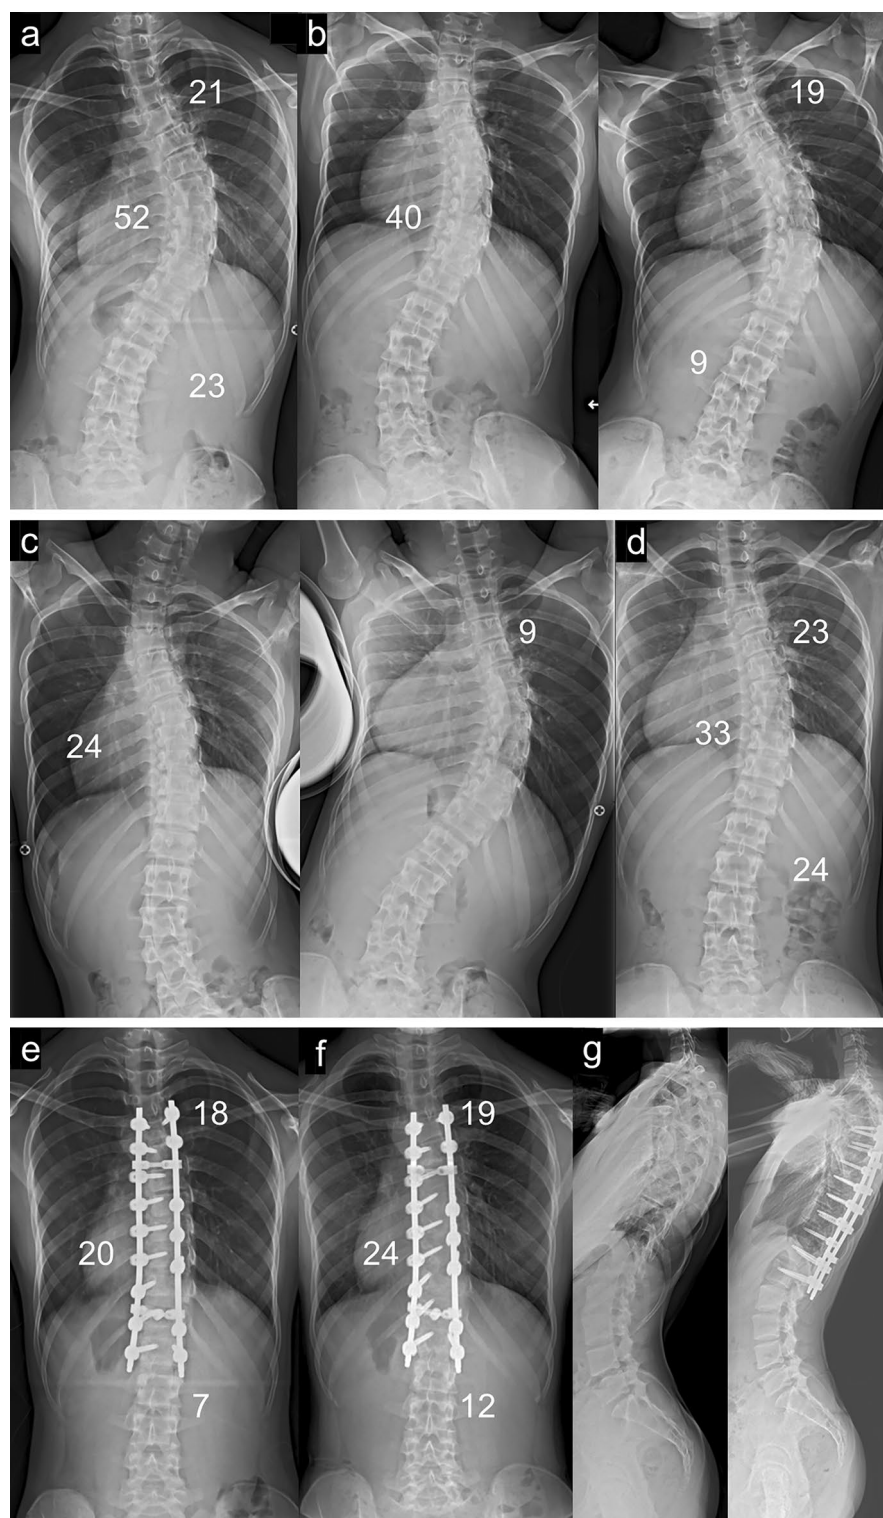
A 17-year-old female patient with Lenke type 1 adolescent idiopathic scoliosis. (a) Standing posteroanterior radiographs before surgery. (b) Active side-bending radiographs. (c) Fulcrum-bending radiographs. (d) Traction-bending radiographs. (e) Standing posteroanterior radiographs at the 1-month follow-up. (f) Standing posteroanterior radiographs at the 2 years follow-up.
